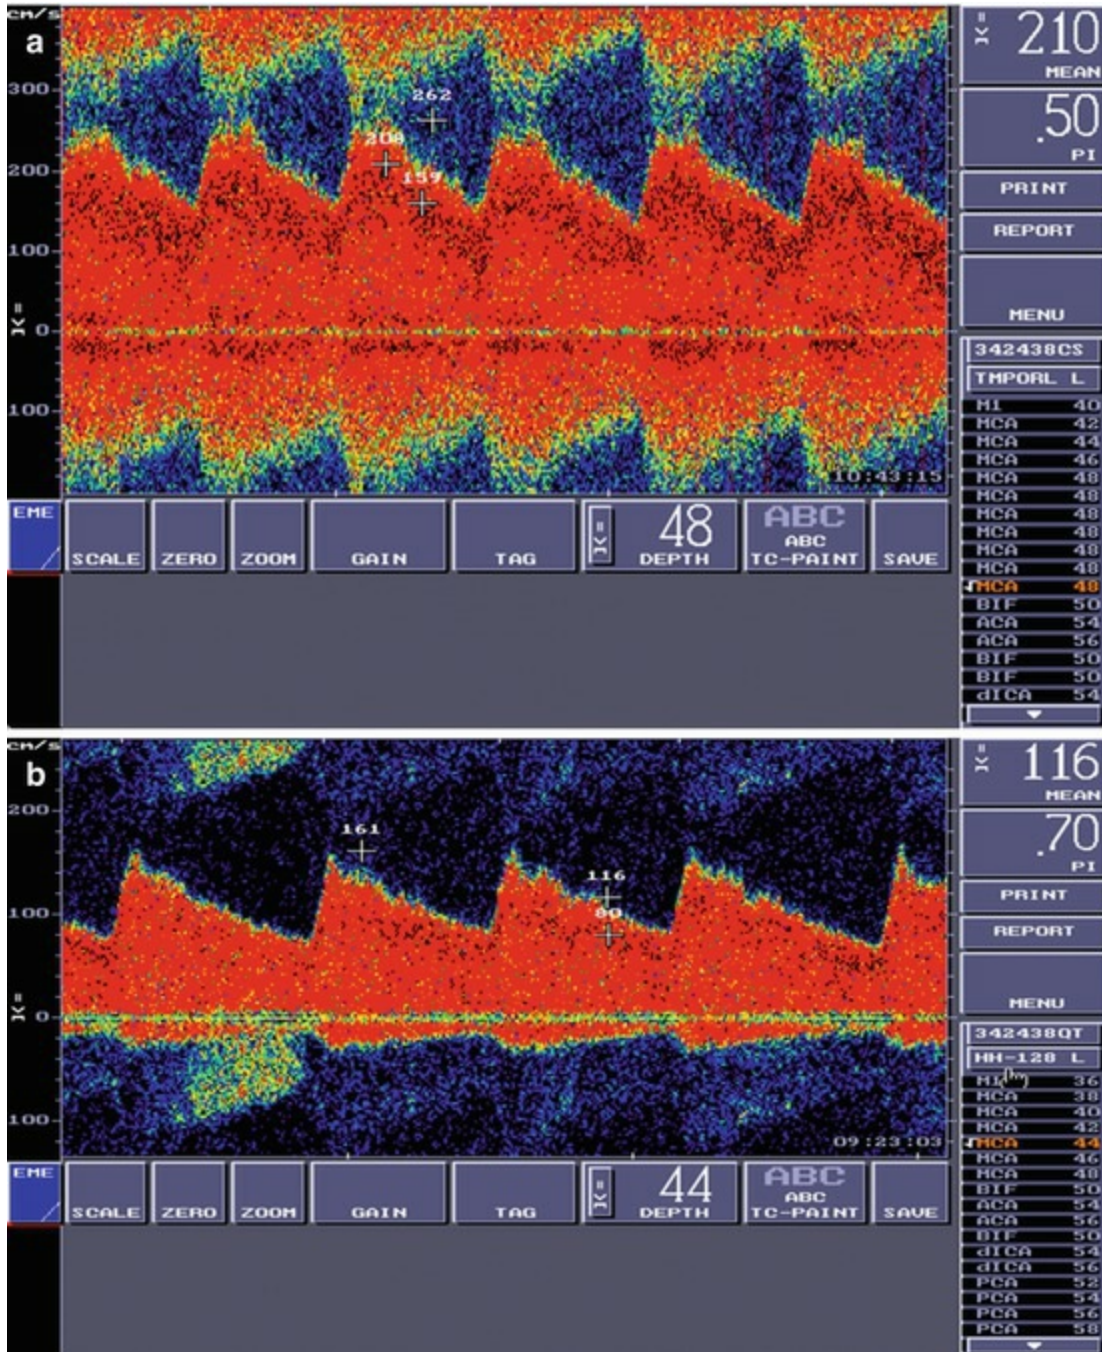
TCD ultrasound velocity waveform from patients with SCD. In (a), the patient has high TCD velocity values and thus is at risk for stroke and (b) is the same patient after 12 months of chronic blood transfusion therapy and TCD velocity has normalized
